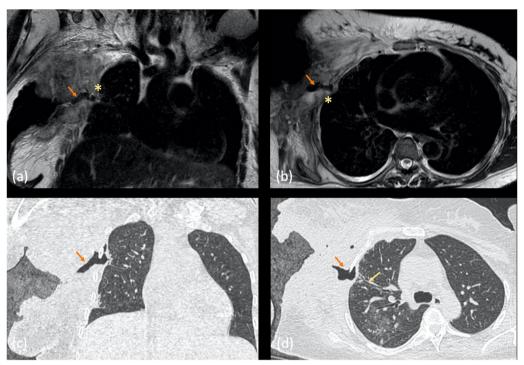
Chest MRI and CT findings of PBL in the same patient, complicated with bronchopleural cutaneous fistula. Chest MRI [(a) coronal and (b) axial T2-weighted images] and chest CT scan [(c) coronal and (d) axial images on a lung window]. MRI images show the extensive ulcerated lesion in the right breast with heterogenous signal intensity, extending to the ipsilateral axilla and deeply invading the chest wall, associated with pleural thickening (yellow asterisk). A fistulous tract filled with gas can also be seen (orange arrow), communicating with a peripheral bronchus of the right lung (yellow arrow) and extending into the pleural space and into the chest wall, traversing the breast lesion—it corresponds to a bronchopleural cutaneous fistula
